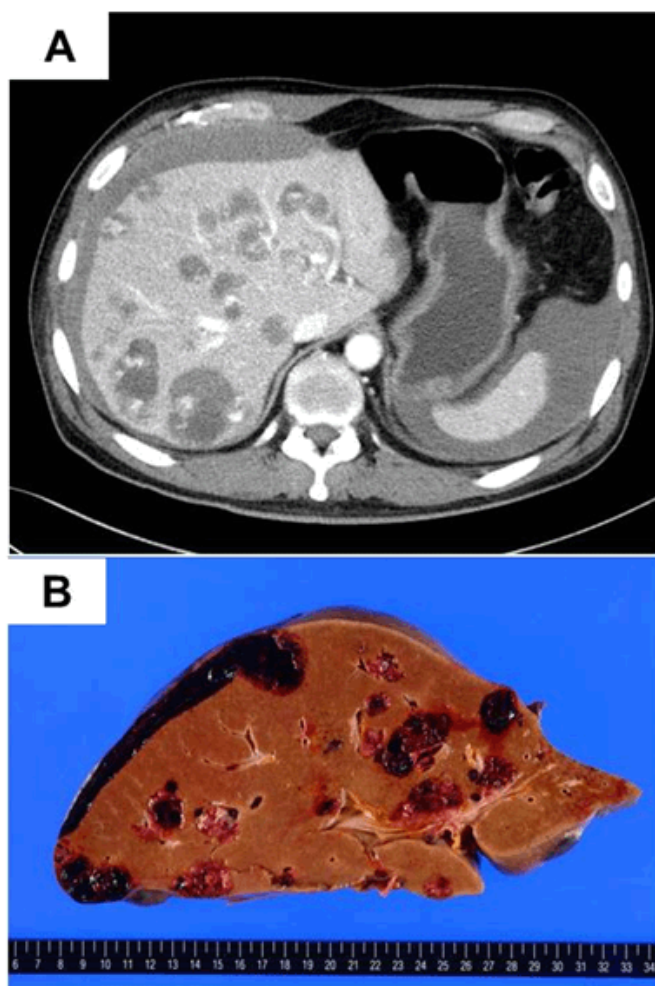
(A) Contrast-enhanced computed tomography scan of the abdomen, showing intraperitoneal hemorrhage due to multiple liver metastases, (B) At autopsy, fatal massive intraperitoneal hemorrhage arising from liver metastases was demonstrated.
